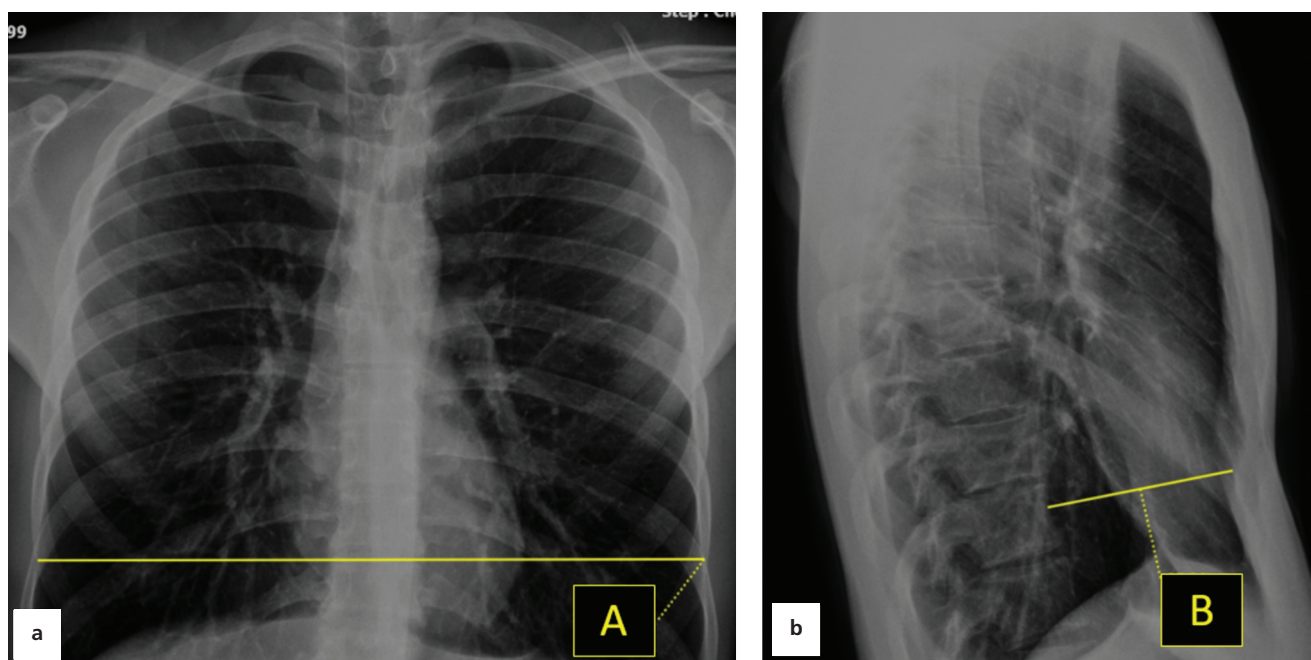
The figure shows how the measurements determining the Haller index were performed. Posteroanterior (a) and lateral (b) two-view chest radiography of a 24-year-old male with pectus excavatum. A: the transverse diameter of the thorax is measured from the inner surface of the costae on both sides, where the diameter is widest; B: measurement of the shortest distance between the anterior edge of the vertebral body and the posterior surface of the sternum on lateral radiographs.
